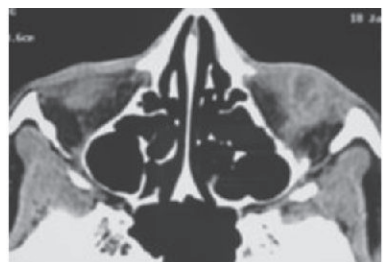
CT scan (axial section) - diffuse contrast enhancing soft tissue thickening anterior to the orbital septum (left side)
